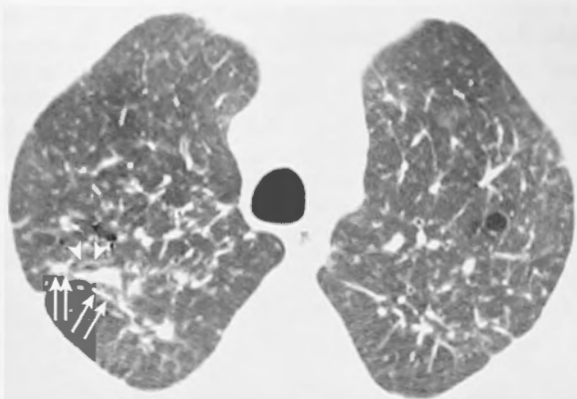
Axial high-resolution CT scan of chest demonstrating characteristic findings in domestic acquired particulate lung disease, including nodular interlobular septal thickening (arrowheads) and bronchovascular thickening with nodular appearance (double arrows). (Modified from Diaz JV, Koff J, Gotway MB, et al: Case report: a case of wood-smoke-related pulmonary disease, *Environ Health Perspect* 114:759-762, 2006.)
